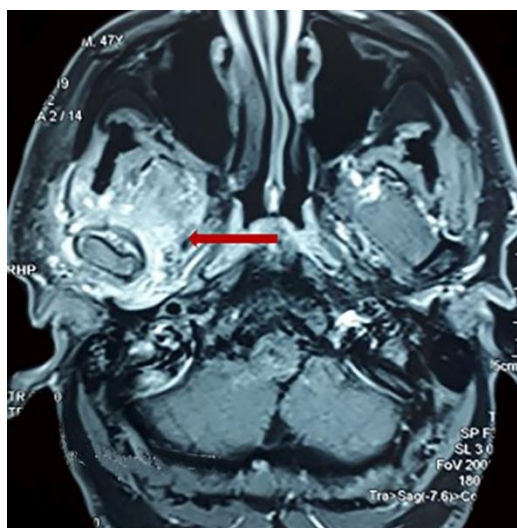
Axial magnetic resonance imaging FLAIR after gadolinium injection showing abnormal soft tissue of the right skull base with heterogeneity in the parapharyngeal space and the infra-temporal fossa (arrow)
